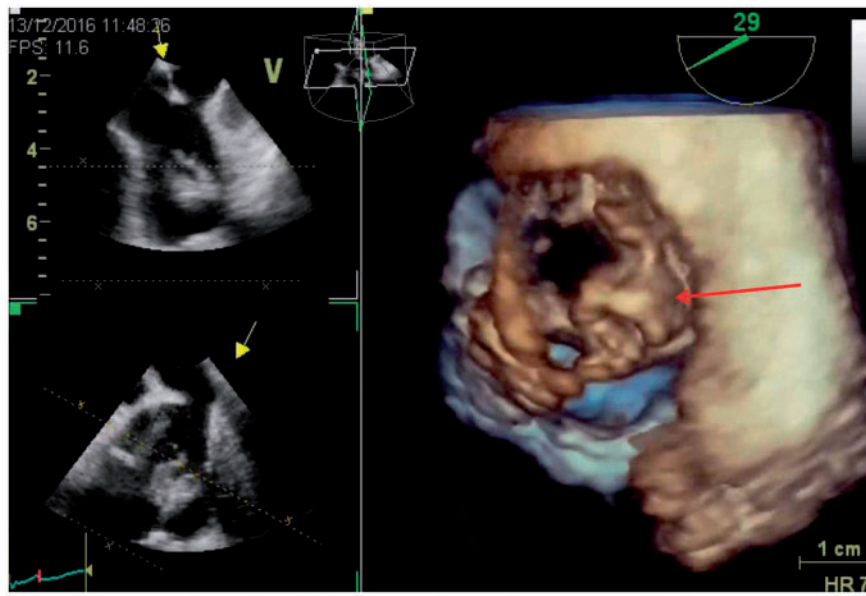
3D reconstruction from the transoesophageal echocardiogram. Red arrow pointing to the mass arising from the pulmonary prosthesis.
